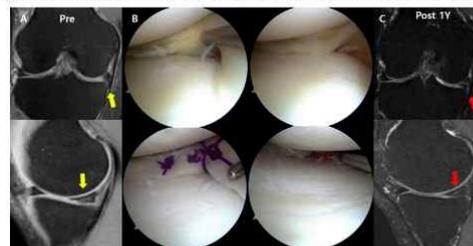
Case 2: A 43-year-old male presented with medial joint line pain for over 11 months. Arthroscopic evaluation revealed a horizontal flip complex tear of the medial meniscus impinging on the medial tibial spine. The tear was resected and repaired using a suture hook and five stitches with PDS-0, along with the application of a blood-collagen mixture. On 1 year follow-up MRI, the medial meniscus demonstrated a well-maintained shape and a decreased signal intensity, corresponding to grade 1.
